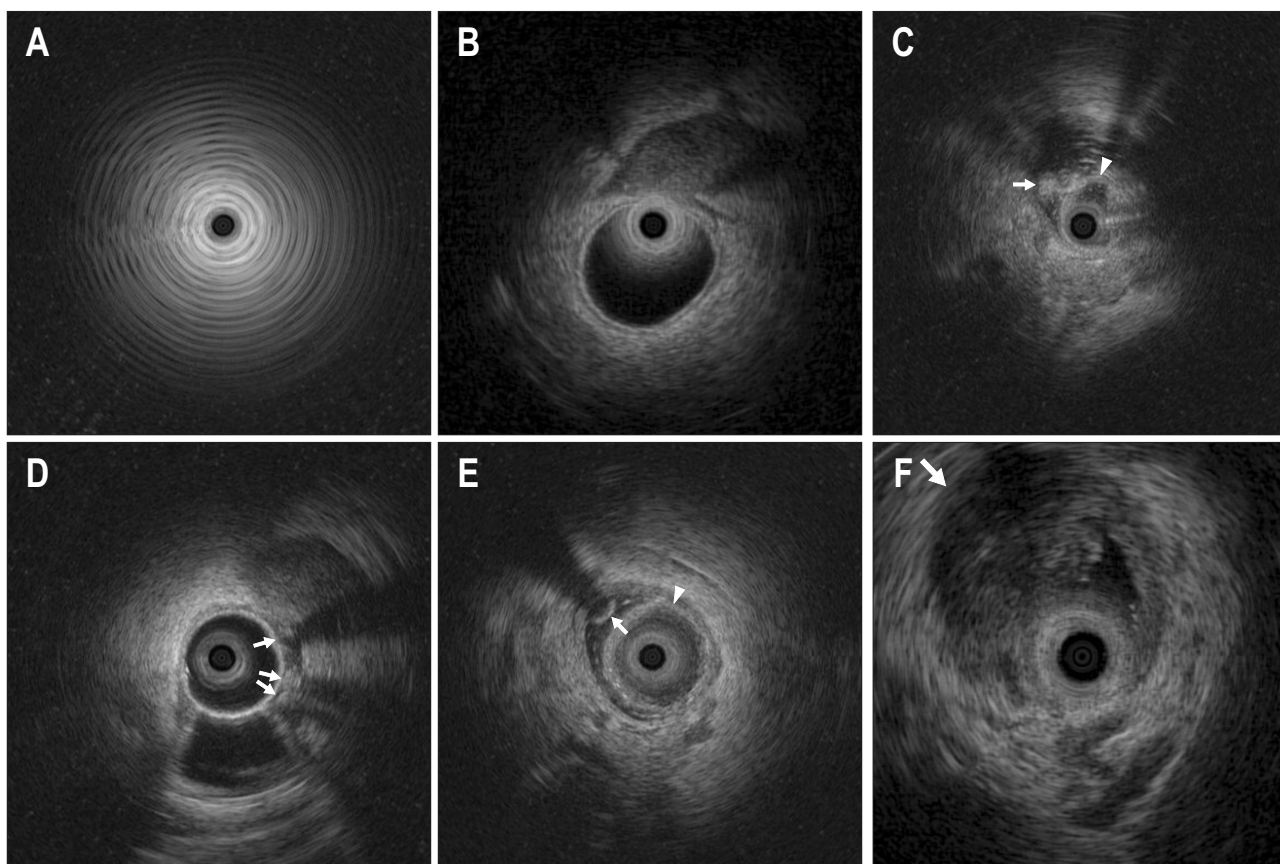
(A) Extensive pneumobilia as shown by conventional intraductal ultrasonography (IDUS). (B) Extrahepatic bile duct wall (same area in Fig. 2A), visualized with the balloon-sheathed catheter IDUS. (C) Remnant stones (arrow), detected with the balloon (arrowhead)-sheathed catheter IDUS. (D) Remnant stones (arrows), detected with the balloon-sheathed catheter IDUS. (E) Remnant stones (arrow), detected with the balloon (arrowhead)-sheathed catheter IDUS. (F) Cholangiocarcinoma (arrow), detected with the balloon-sheathed catheter IDUS in common bile duct.
